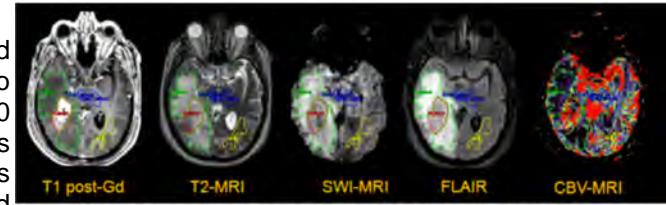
Sample of registered images (T1 post-Gd, T2-MRI, SWI-MRI, FLAIR, and CBV-MRI) and ROI's (tumor in red, edema in green, NWM in yellow, and thalamus in blue) for a 57-year-old male with WHO grade IV glioblastoma.
